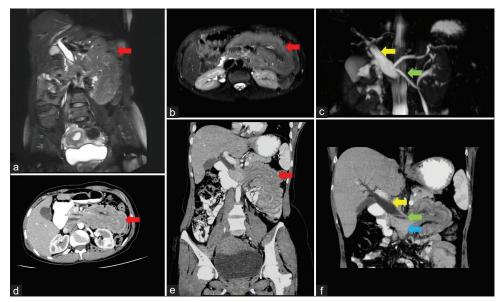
Coronal and axial, MRI, and CT images show telescoping of the duodenum into jejunum (red arrows in a, b and d, e). MRCP and MinIP CT images show dilated common bile duct (yellow arrow in c and f), prominent pancreatic duct directed toward left (green arrows in c and f), and head of the pancreas pulled leftward (blue arrow in f). MRI: Magnetic resonance imaging, CT: Computed tomography, MRCP: Magnetic resonance cholagiopancreaticography, and Min IP: Minimum intensity projection.
